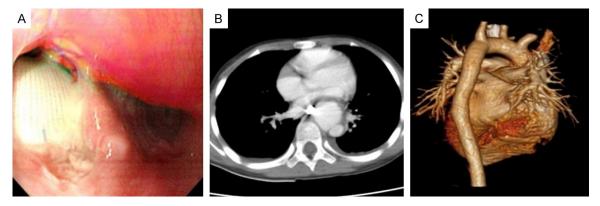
A: Endoscopic esophageal rupture titanium clip closure treatment. B: Chest CT enhancement prompted thoracic aortic pseudoaneurysm, class round slightly higher density, enhanced scan enhancement and thoracic aorta similar, size 25×27 mm. C: Thoracic aortic pseudoaneurysm after surgery, CAT lumen clear, intimal intact.
